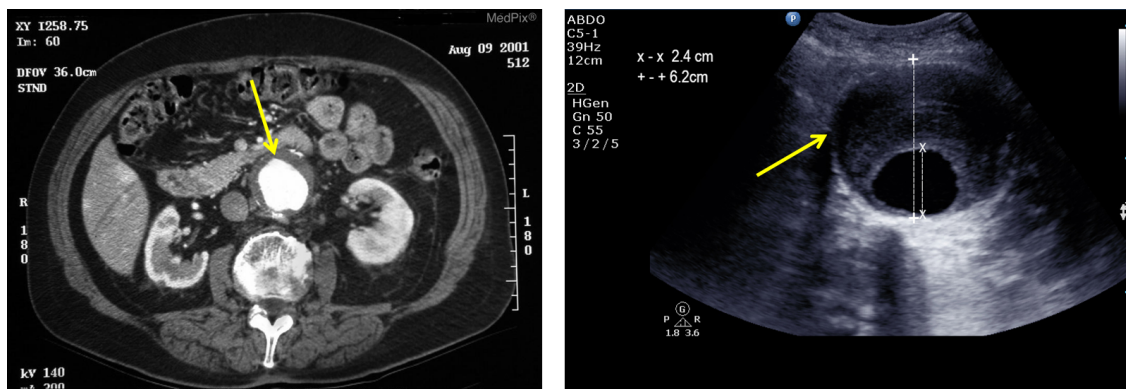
Imaging diagnosis. Left: Abdominal CTA with AAA pointed. World Federation for ultrasound in medicine and biology (WFUMB). Right: Abdominal US with AAA pointed. MedPix (2013). Accessed on 02-02-2021.
